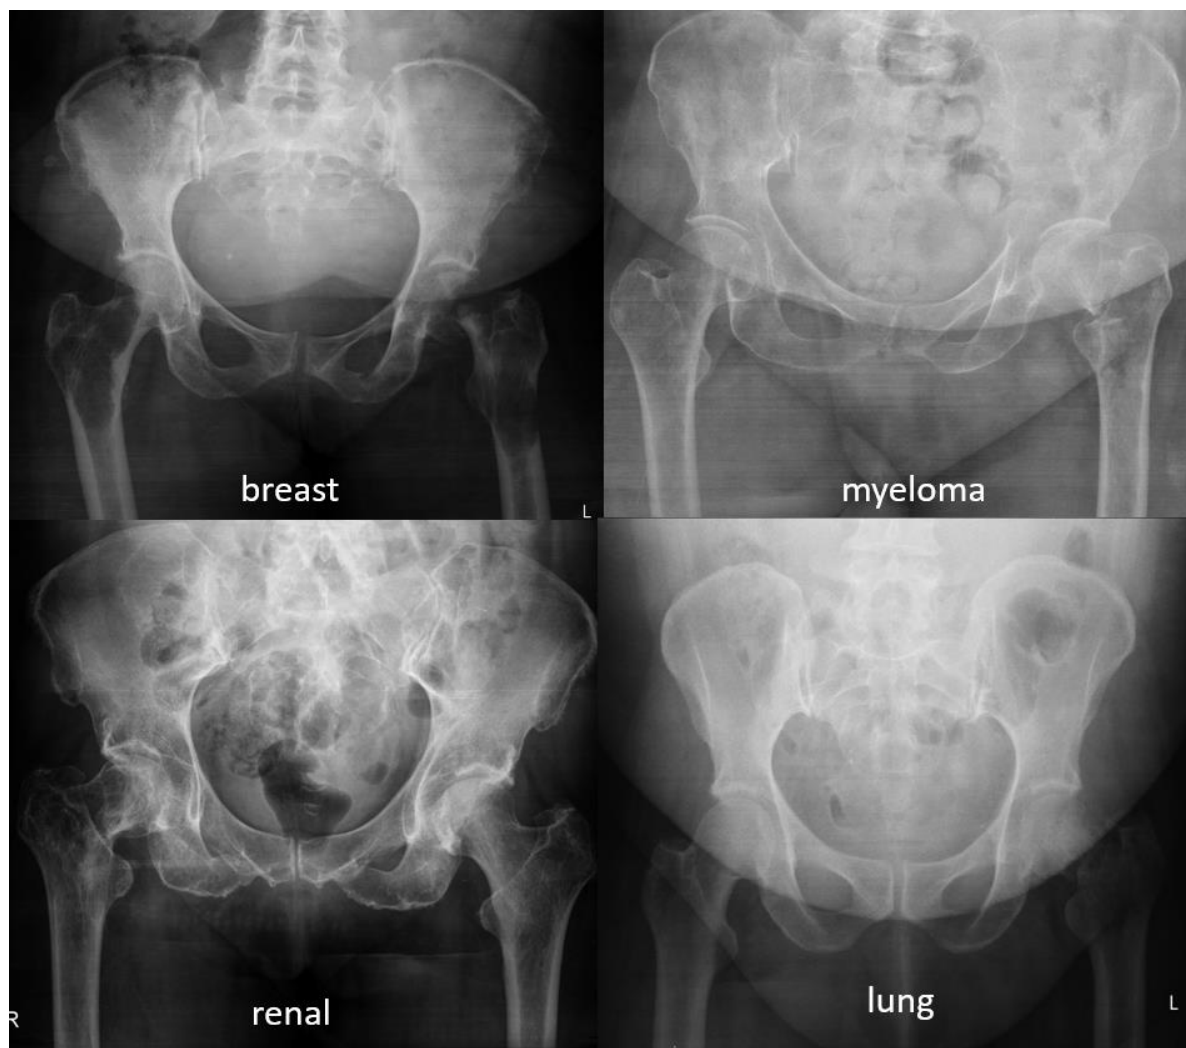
Anteroposterior Radiographs of patients from our study presenting with pathological fractures with the source of primary denoted below each image.
